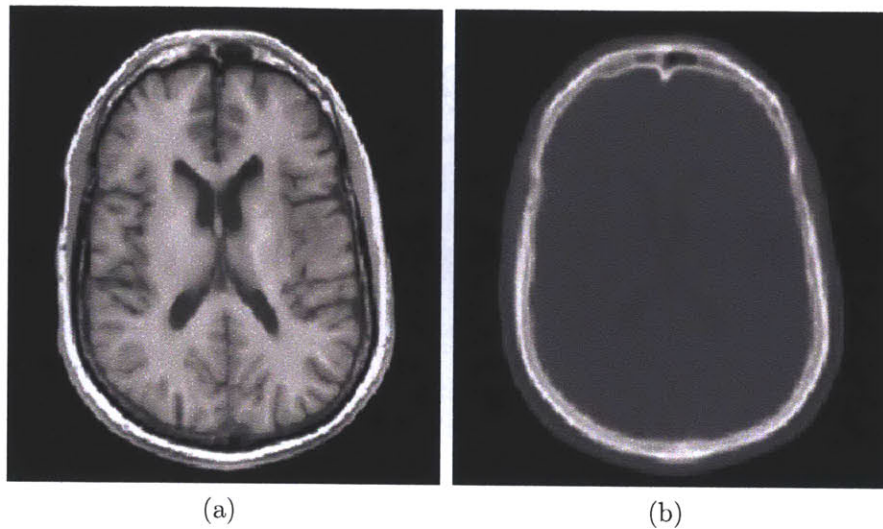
CT and Structural MRI. Axial cross-sections of a T1-weighted structural image (a) and CT (b) of a patient at Brigham and Women's Hospital have substantially different intensity properties. The MRI shows excellent contrast within the soft tissue of the brain, while the CT shows strong contrast between bone and soft tissue.
